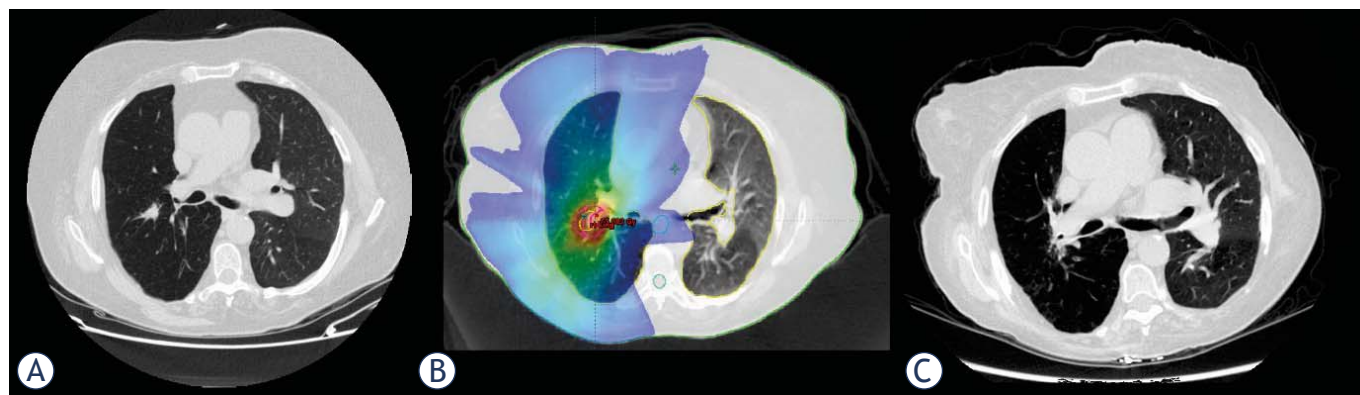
(A) Pretreatment CT demonstrating a central nodule in the right lower lobe (B) Radiation field arrangement and dose color wash for SBRT (C) CT 2 months after treatment completion demonstrating a complete disappearance of the target nodule.
